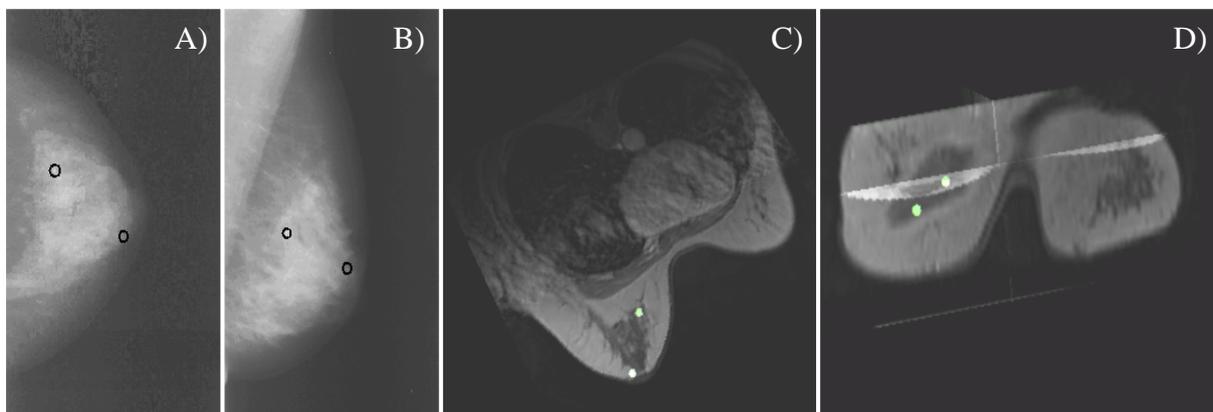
The cranio-caudal A) and lateral B) view showing the location of the two calcifications. C) and D) are 3D position reconstructions of the two calcifications within the MRI volume (volume resliced for clarity)
